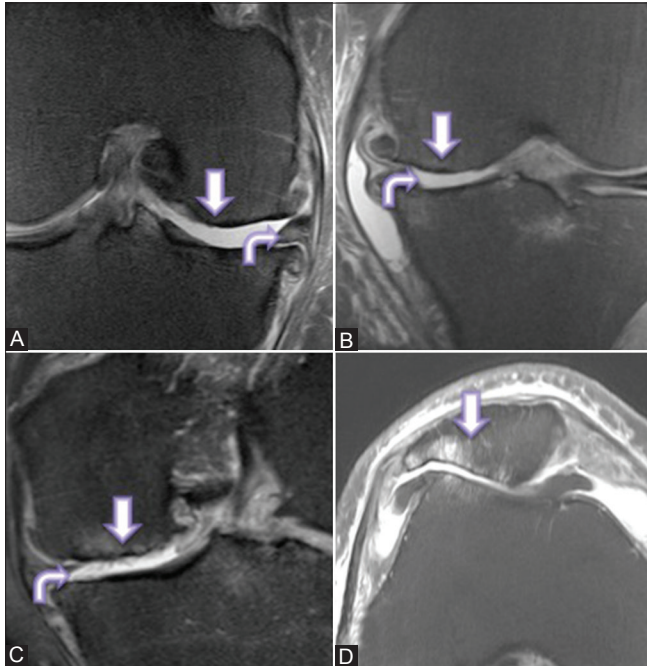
(A-D): Multiplanar FS PD-weighted images in a 56 year old woman who previously underwent arthroscopic partial medial meniscectomy. MRI images of knee joint show established osteoarthritis in medial-lateral femorotibial and patellofemoral articulation. There is a near-complete loss of articular cartilage covering weight bearing surfaces of femoral and tibial condyles as well as non-weight bearing surface of patellofemoral articulation exposing subchondral bone. There are established marginal osteophytosis and subchondral bone sclerosis
